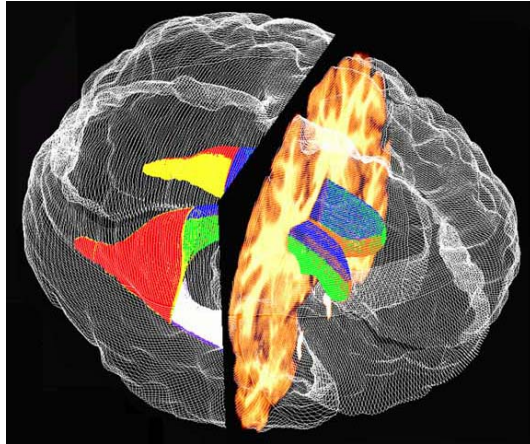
Shape models of the Lateral Ventricles in a Brain MRI Scan.
